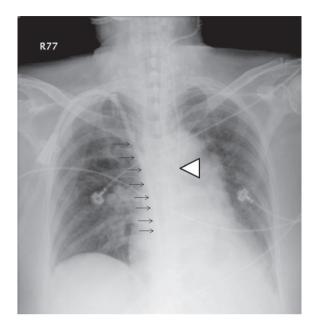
Post-cannulation view of chest, on plain film. Arrow head indicates tip of the central venous catheter. Black arrows indicate Permcath inserted into the right internal jugular vein prior to the insertion of CVC.
